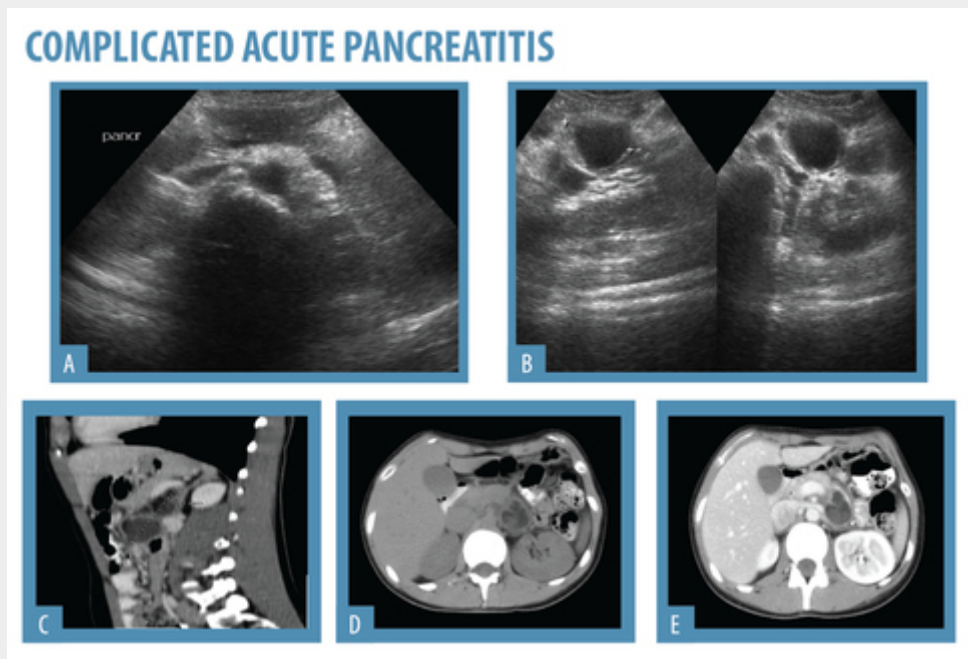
55 year-old patient with history of acute pancreatitis. The patient was hospitalized following yet another episode of acute pancreatitis. Due to worsening of abdominal pain, the patient underwent US (A,B) which revealed an anechoic, oval image, adjacent to the pancreatic tail and afterwards CT (C,D,E) that also shows an enlarged pancreas and a fluid-filled collection adjacent to the pancreatic tail, with some peripheral enhancement.
